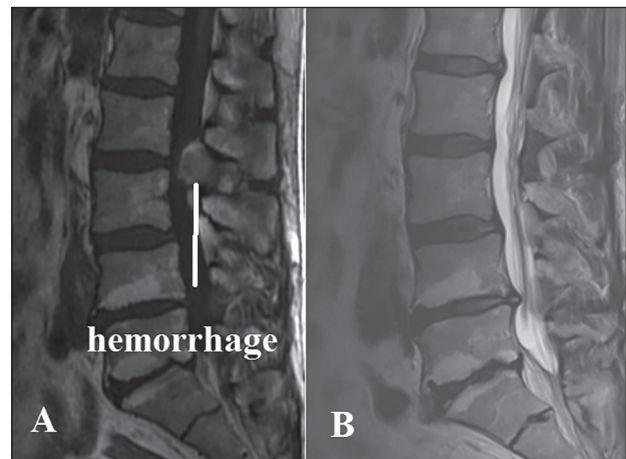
Shows preoperative and postoperative sagittal MR images of patient
